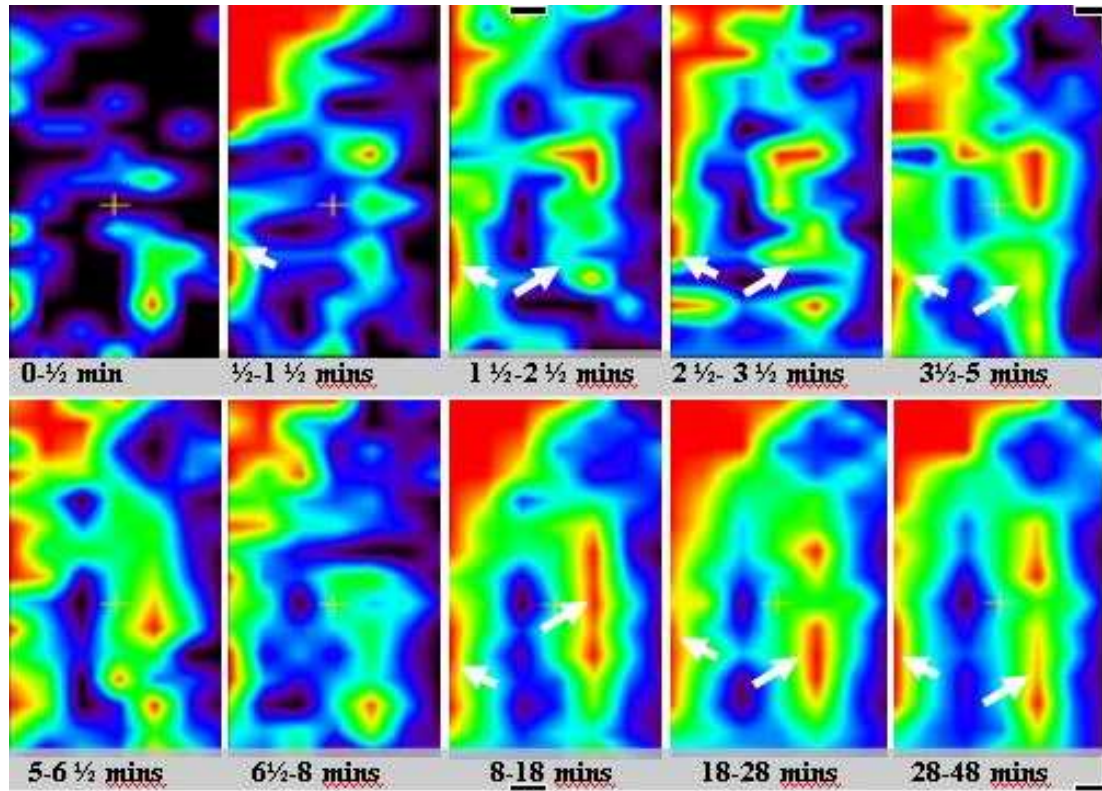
Planar images for a $[^{18}\text{F}]\text{FDG}$ study.
